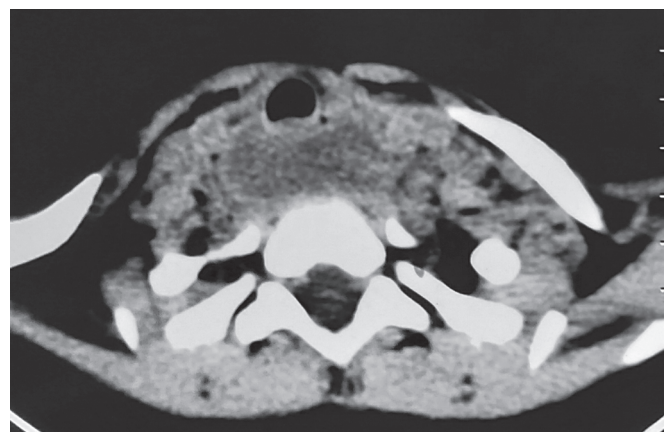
CT neck showing retropharyngeal abscess
